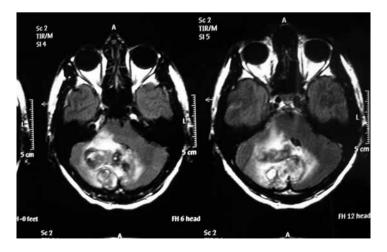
Axial T2 FLAIR magnetic resonance with heterogenicity signal compatible with ischaemic stroke transforming to hemorrhagic stroke
